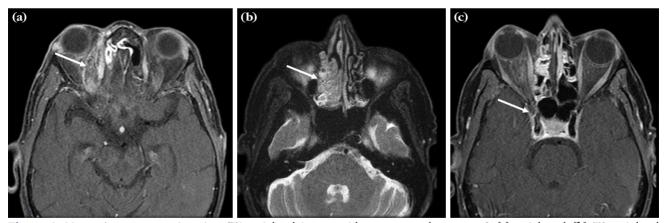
Magnetic resonance imaging (T1-weighted image with contrast enhancement) (a) axial and (b) T2-weighted image views of the brain at the level of the orbits. (a) Contrast-enhanced T1-weighted sequences reveal a hyperintense material filling the right ethmoidal sinus, and (b) inflammatory changes with gadolinium enhancement in the sinus mucosa extending through the medial wall of the orbit and the right medial rectus muscle. (c) Signal intensity with filling defects on post contrast images in the right cavernous sinus (white arrows).
